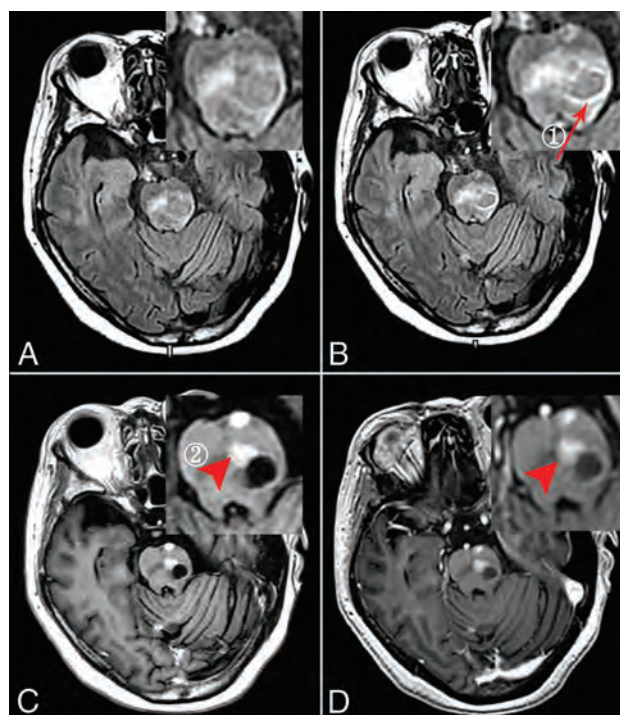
A 62-year-old woman with ring (①, ≥ 5 mm, *arrow*) and solid (②, ≥ 5 mm, *arrowhead*) enhancing brain metastases. A, Nonenhanced T2 FLAIR. B, Phase 3 half-dose CE-T2 FLAIR (①, 3 points; ②, missed diagnosis). C, Half-dose CE-T1WI (①, 1 point; ②, 3 points). D, Routine-dose CE-BRAVO (①, 2 points; ②, 3 points).
